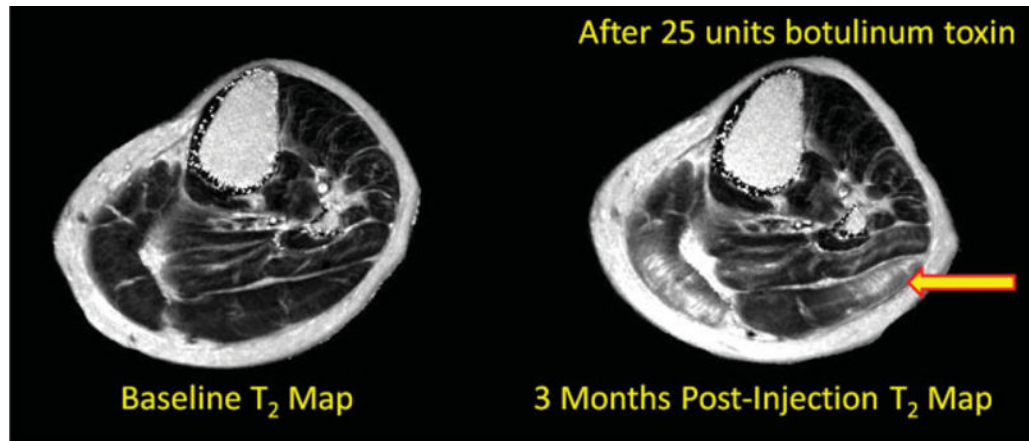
Axial T2 maps at baseline (left) and at 3 months after botulinum toxin injection (right) in a patient undergoing botulinum toxin injection for spasticity management. T2 mapping in this context is used to characterize botulinum toxin diffusion in human muscle using MRI. In the 3-month postinjection image, there are increased T2 values within the lateral head of the gastrocnemius muscle (yellow arrow).
